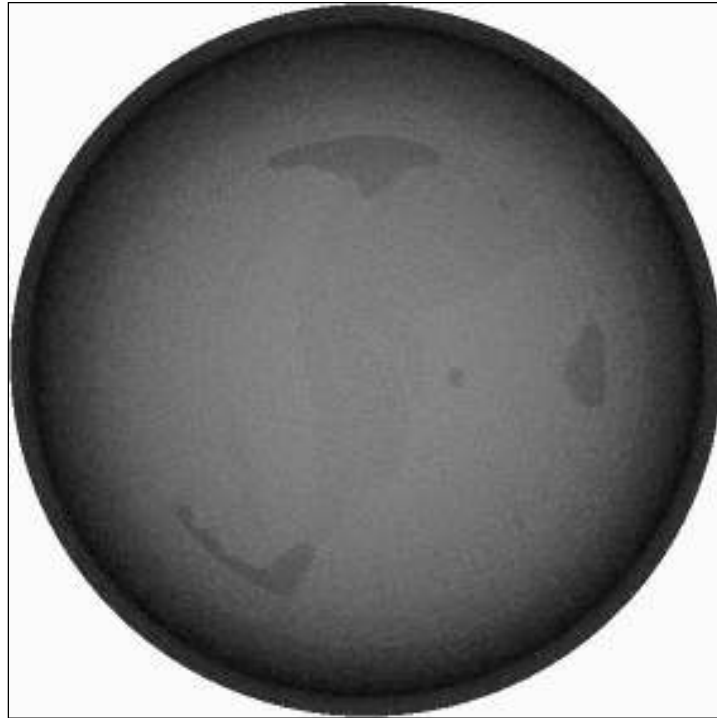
Reconstructed CT slices from the scan with the GaAs Medipix2 detector using a THL set for 14.45 keV. Reconstructions were performed using the Octopus software.
